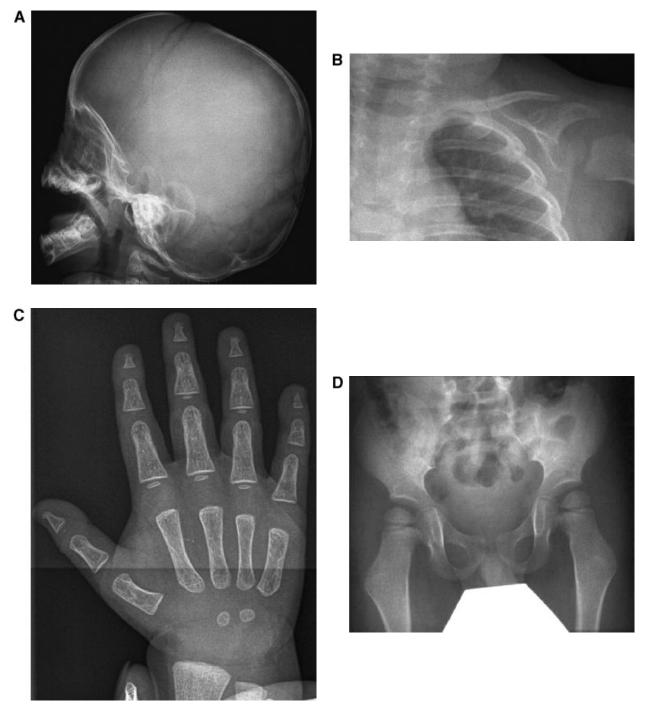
Radiographs of Dutch Patient 3 at the age of 2 years. A: Skull. Note relatively large neurocranium compared to the viscerocranium (especially the mandible), open anterior fontanel, thin cranial vault, and mild wormian bone formation at the occiput. B: Clavicle. Note mild tapering of the distal part. The ribs are normal. C: Hand. Note limited osteolysis of the distal phalanx of the 2nd and 5th finger. D: Pelvis. Note expressed coxa valga.
